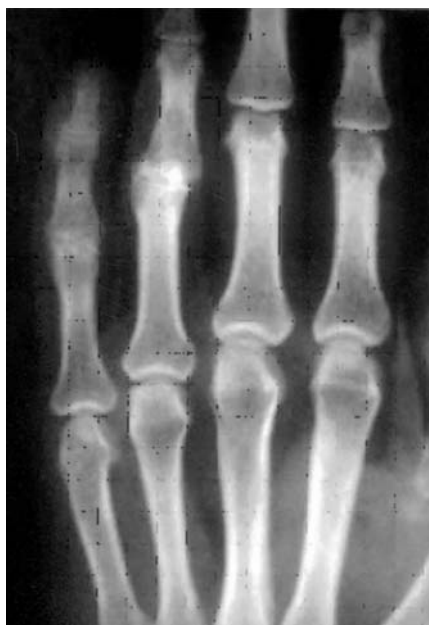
Preoperative X-ray for the same patient showing obliteration of both joint spaces.
